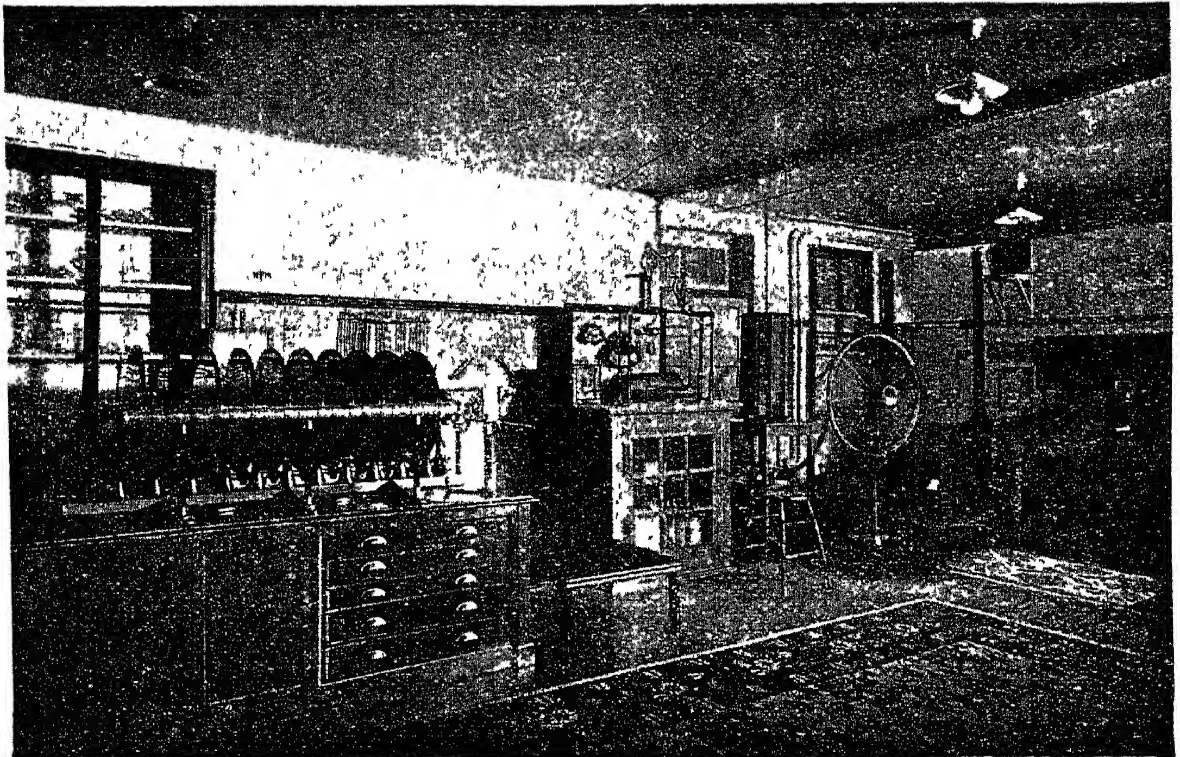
The writer's Laboratory, showing Gaiffe's new X-rays and High-frequency Apparatus, and 25-plate Influence Machine.
